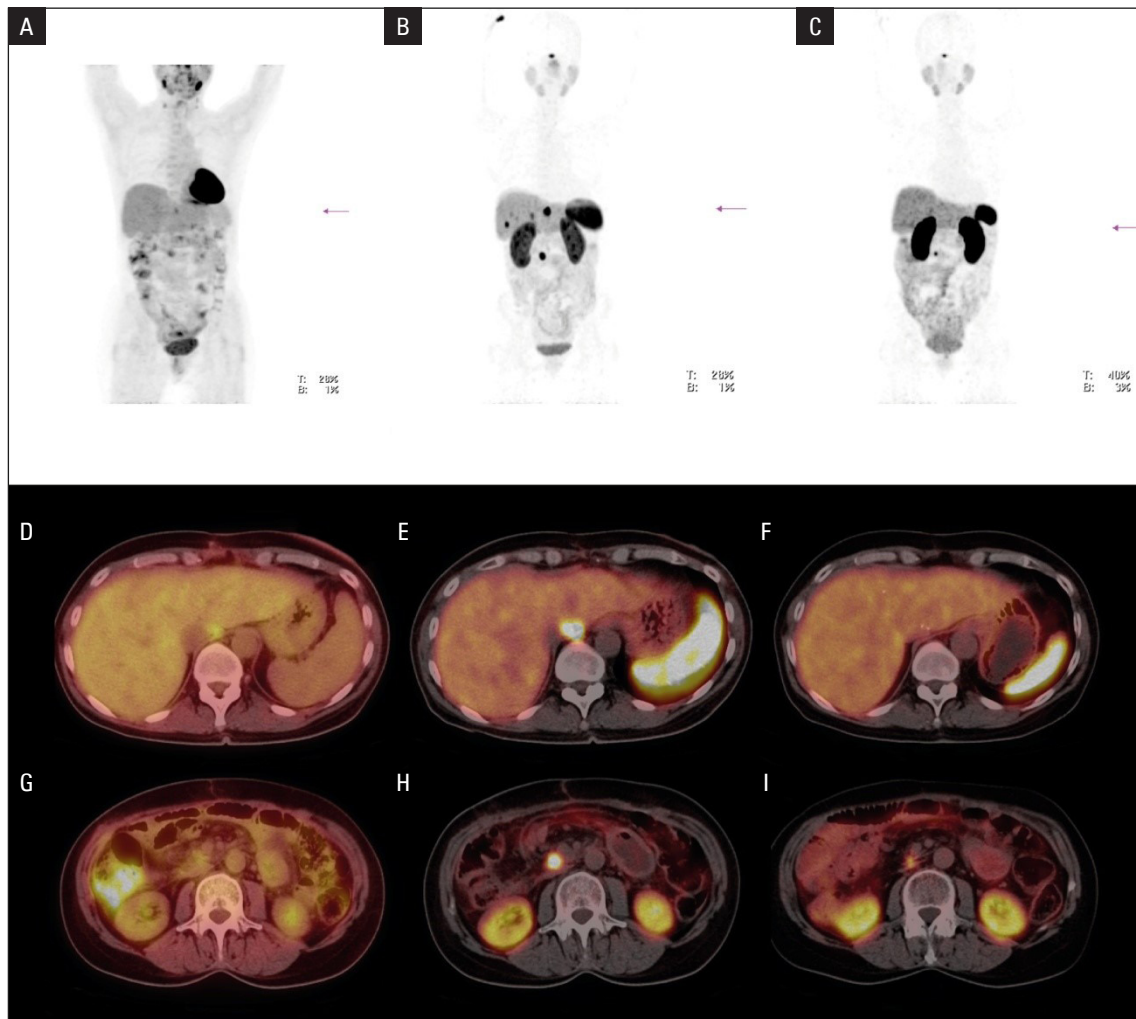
Example of tandem [⁹⁰Y]/[¹⁷⁷Lu]Lu-DOTATATE therapy effect. A 31-year-old man with primarily non-resectable, non-functional pancreas NET G1 with metastases to lymph nodes, bones, and the liver. A — [¹⁸F]FDG PET MIP; B — [⁶⁸Ga]Ga-DOTATATE PET MIP; C — [⁶⁸Ga]Ga-DOTATATE PET MIP; D, G — [¹⁸F]FDG PET/CT before treatment without uptake in the primary tumour and bone metastases; E, H — [⁶⁸Ga]Ga-DOTATATE PET/CT before treatment with high uptake in the primary pancreas tumour and bone metastases; F, I — [⁶⁸Ga]Ga-DOTATATE PET/CT after 6 months of follow-up showed partial treatment response within the primary tumour and bone metastases
